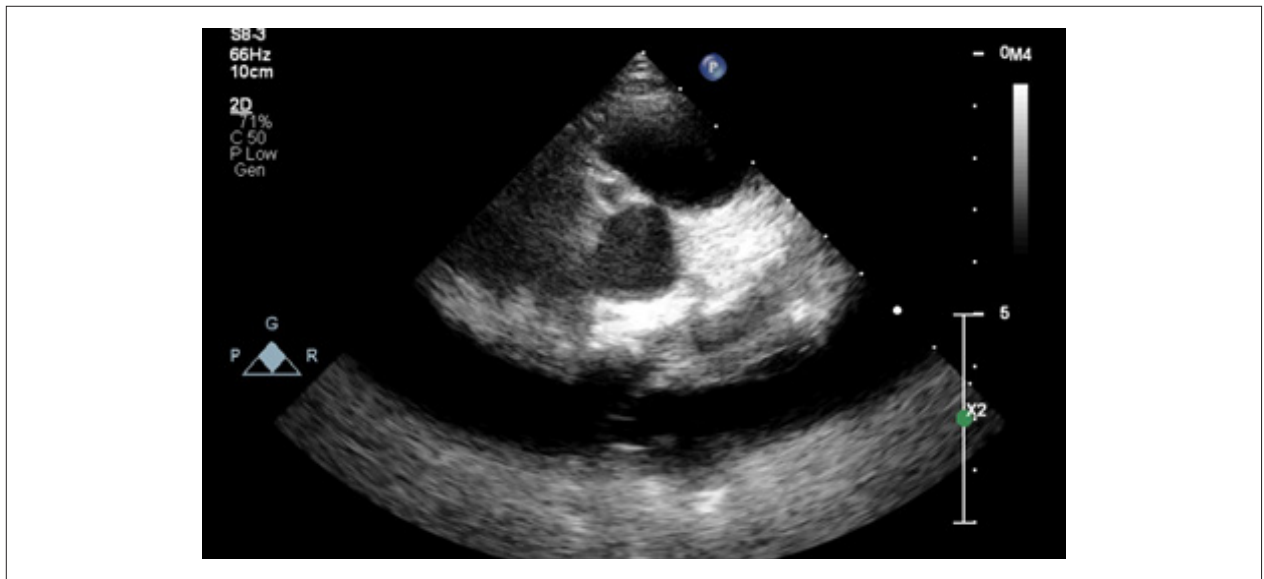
Transthoracic echocardiography demonstrated saccular dilations in the middle of the right coronary artery.
